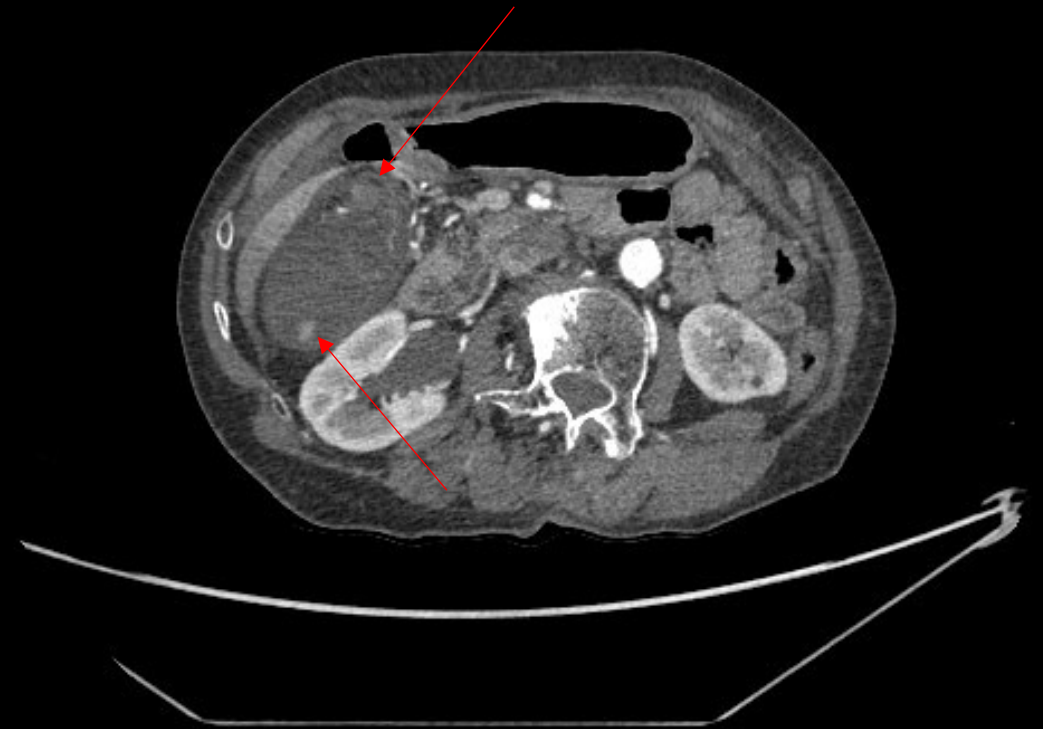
Post-contrast axial CT
